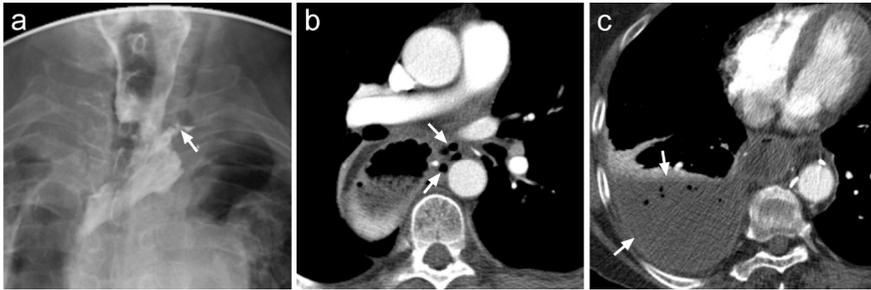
Examples of patients with leakage of the cervical esophagogastrostomy. Contrast swallow examination revealed a small fistula at the left side of the anastomotic site (*arrow*) without extension to the thoracic cavity in a patient with cervical wound crepitus without altered SIRS criteria as a result of leakage confined to the neck (a). CT demonstrated mediastinal extra-luminal air collections (*arrows*) in another patient in who pus was successfully evacuated by mediastinal drainage through the neck (b). In a third patient, cervical leakage exhibited a right dorsal pleural empyema (*arrows*) which required evacuation through video-assisted thoracoscopy (c).
